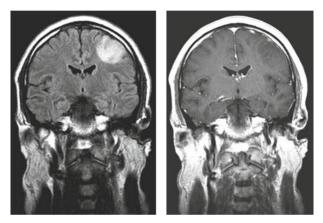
Left frontal oligodendroglioma grade II which is undistinguishable from any other glioma by FLAIR or T1 weigted MR
